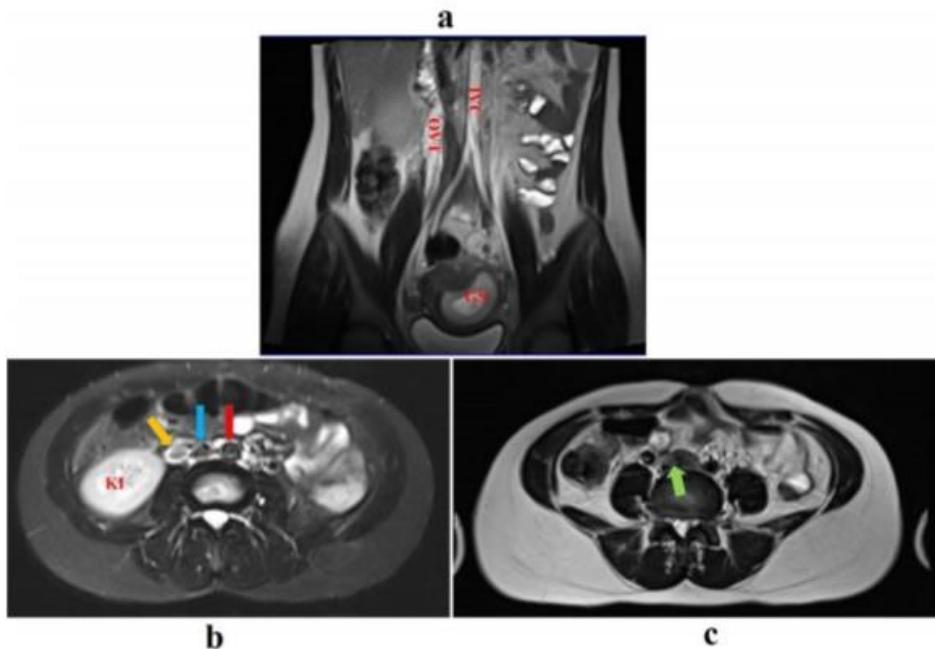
Coronal and axial without contrast-enhanced Magnetic resonance imaging (MRI) image showing a Ovarian vein thrombosis (OVT). yellow arrows show ovarian vein thrombosis, red arrows show aorta artery, blue arrows show inferior vena cava and green arrows show inferior vena cava bifurcation; Ovarian vein thrombosis (OVT), gestational sac (GS), kidney(KI) and inferior vena cava (IVC) in the abdominal and pelvic sections.
